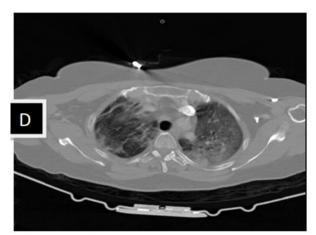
(D). Ground glass images on CT
